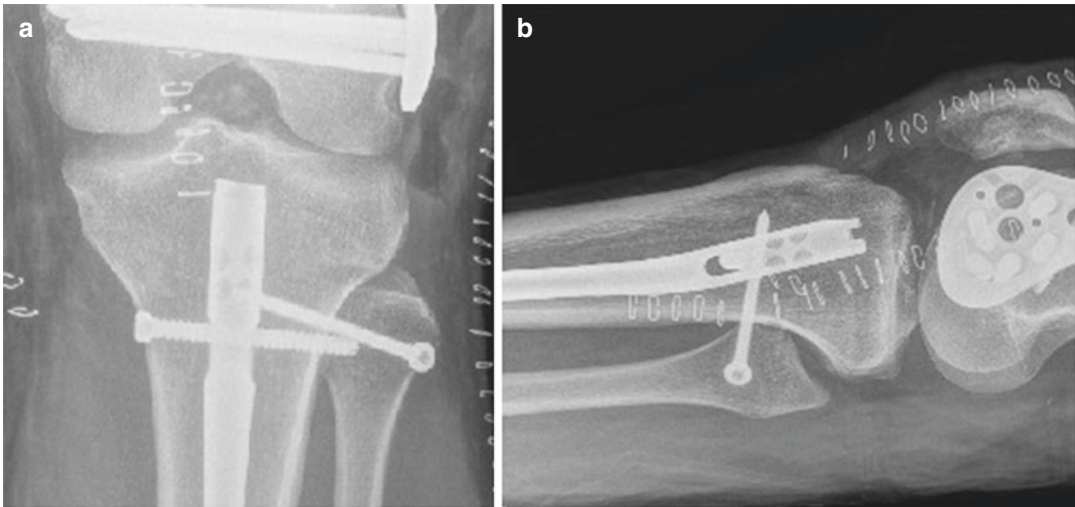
Anteroposterior (a) and lateral (b) radiographs demonstrating fixation of the proximal tibiofibular joint with tricortical screw, intramedullary fixation of the tibia, and distal femoral locking plate
